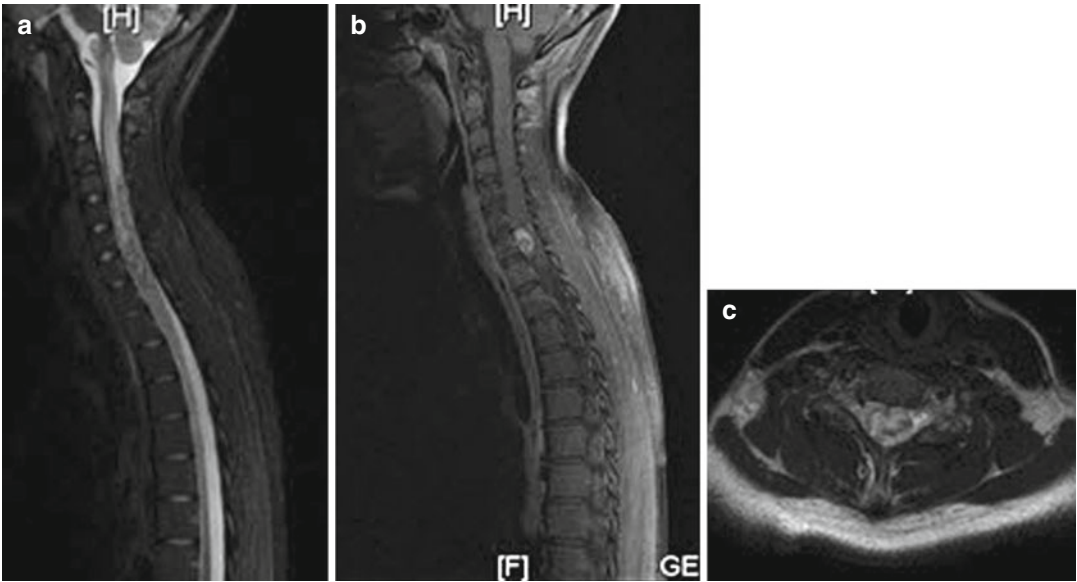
(a) T2-weighted MRI, (b, c) T1-weighted MRI with contrast enhancement showing a hemangioblastoma
